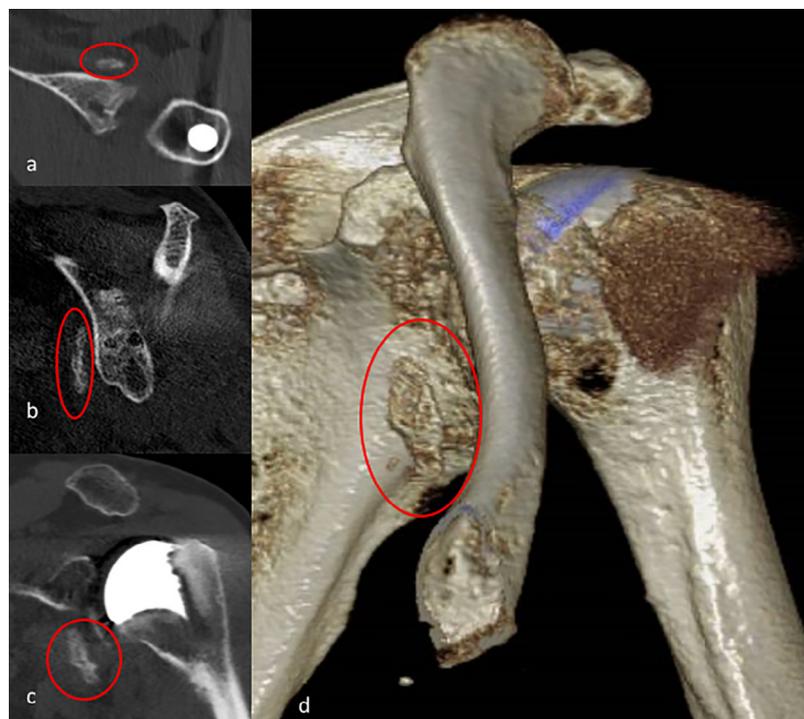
Computed tomography scan performed 10 months after primary TSA demonstrates lesser tuberosity osteotomy (LTO) displaced nonunion of patient described in Fig. 2. Retraction of the LTO to the level of the glenoid is demonstrated in (a) axial, (b) sagittal, (c) coronal, and (d) 3-dimensional reconstructions. The red \circ identifies the LTO.
